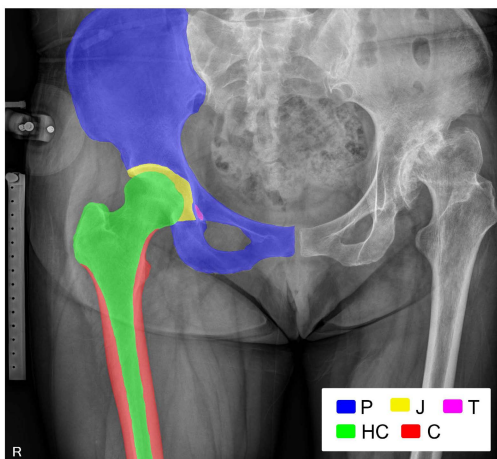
Five regions of radiographic image: P; Pelvis, T; Teardrop, J; Joint space and saucily, HC; Femoral head and canal, C; Cortex.
